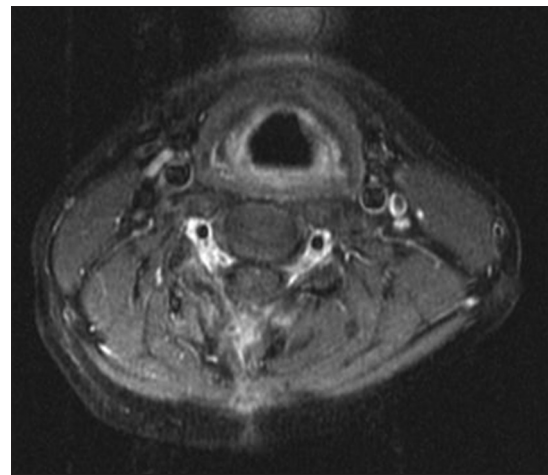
Follow-up magnetic resonance imaging shows no recurrence after 3 years
